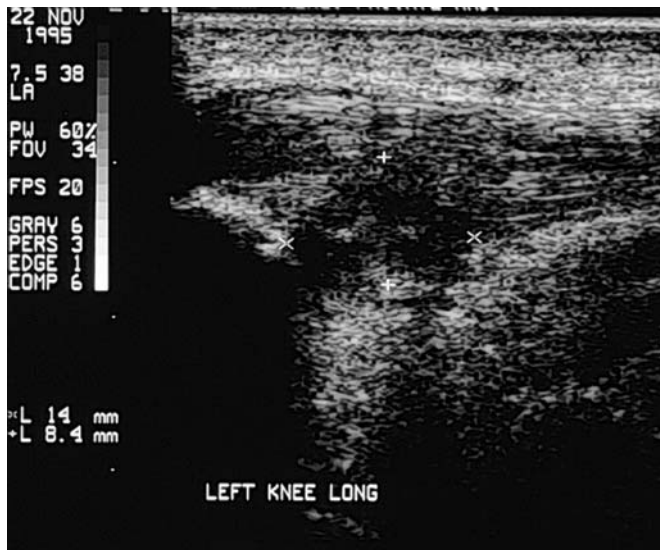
Longitudinal ultrasound scanning of a 25 year old basketball player with patellar tendinopathy. Note the area of hypoechoogenicity.
